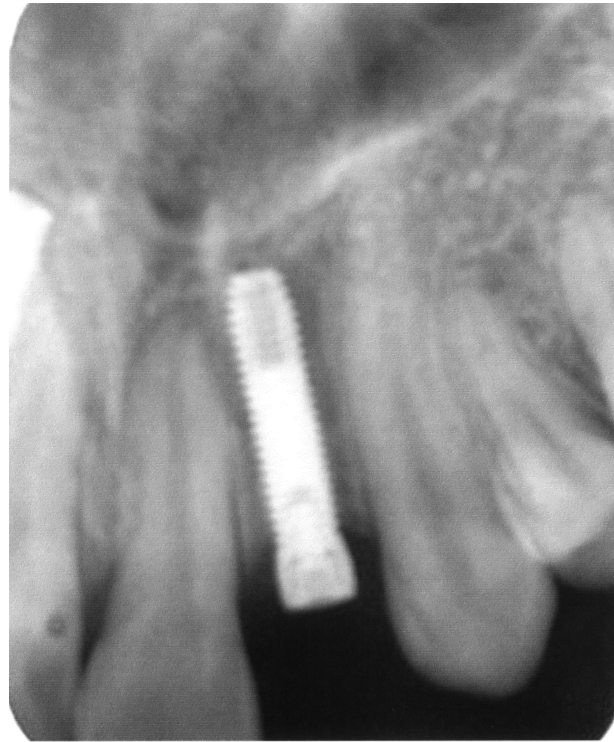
Periapical radiolucency was observed in the apical region of the dental implant.
